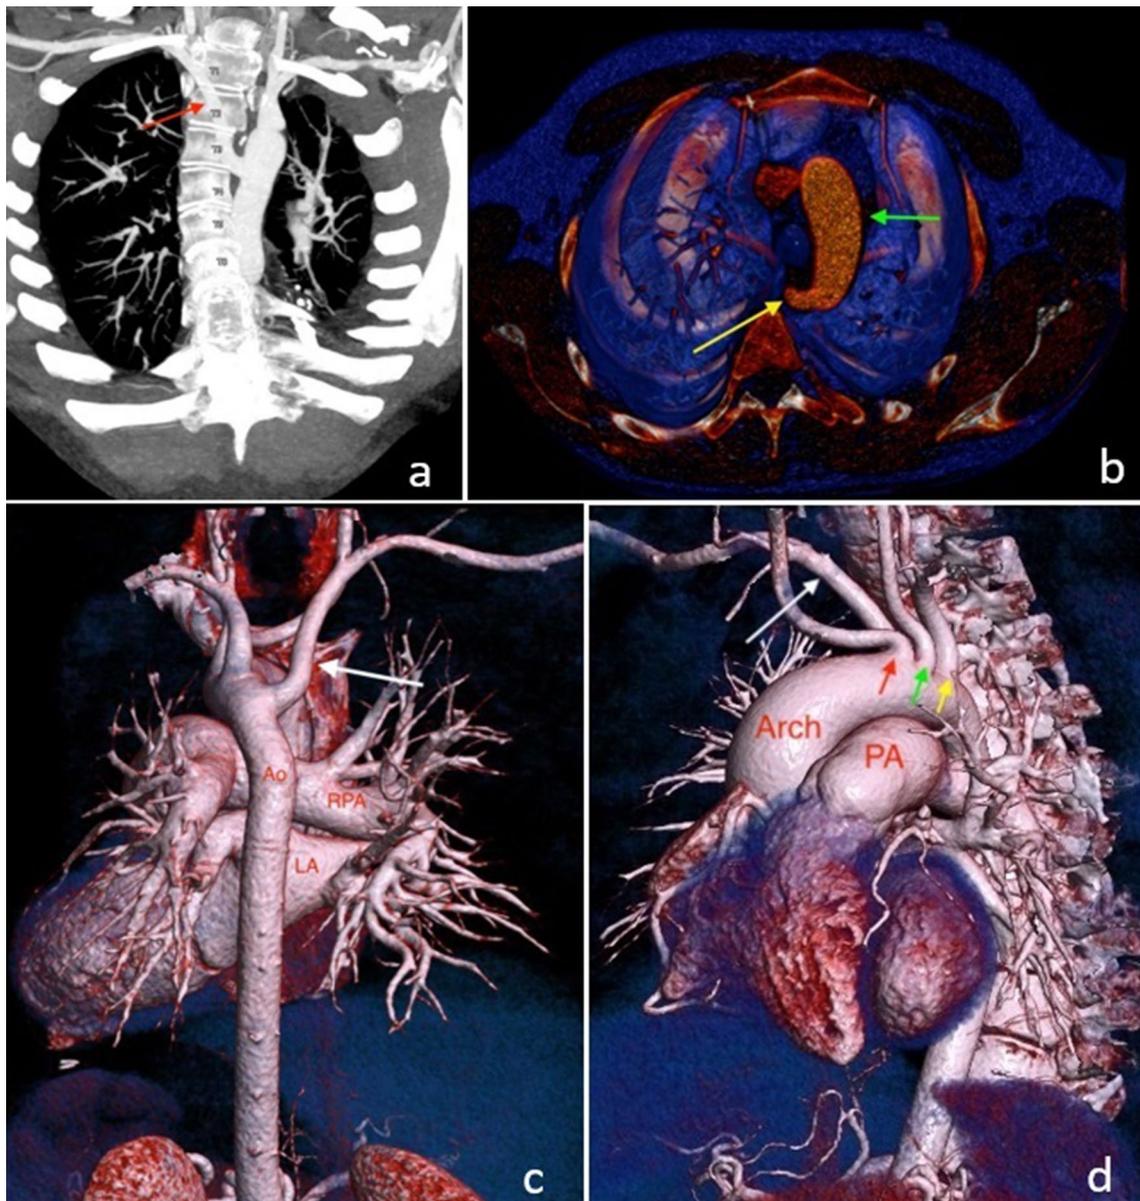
Topography of aberrant right subclavian artery (ARSA): a CTA MIP image, coronal section; ARSA (red arrow); b CTA VRT image, inferior view; aortic arch (green arrow) and ARSA (yellow arrow); c CTA VRT image, lateroposterior view; ARSA (white arrow); d CTA VRT image, lateroanterior view; ARSA (white
